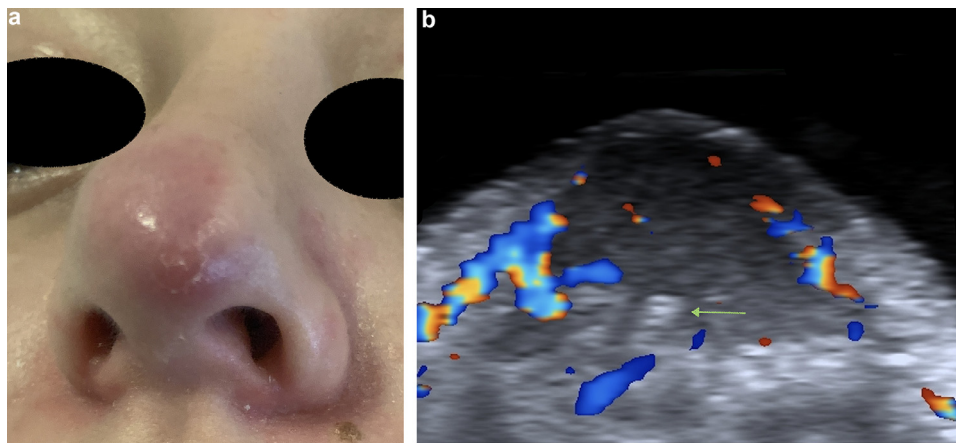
Ultrasound-guided injection of hyaluronidase into an inflammatory hyaluronic acid filler deposit (4–20 MHz linear probe).
